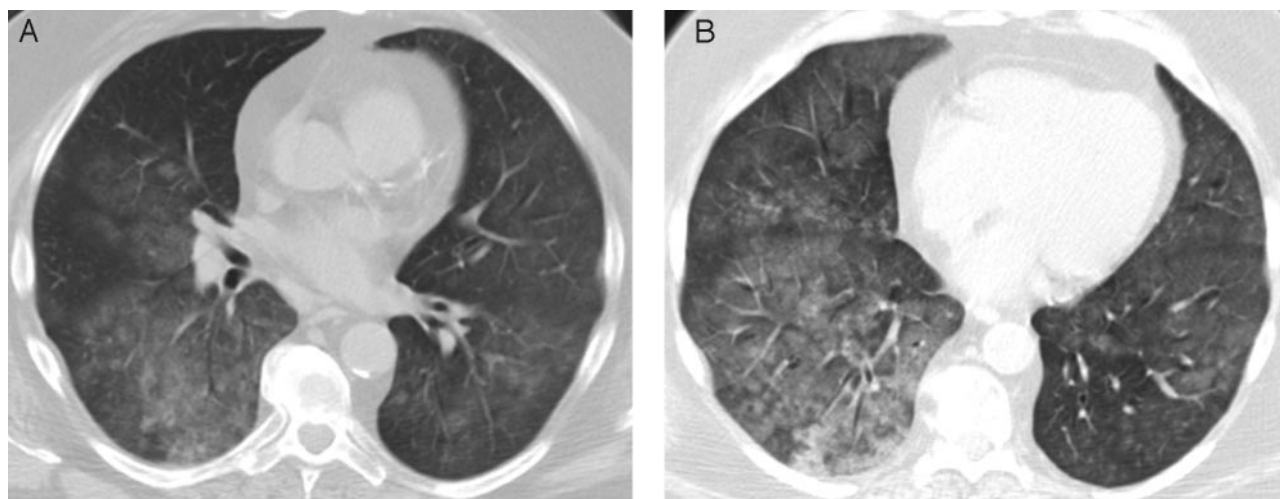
Two slices from the noncontrast high-resolution computed tomogram of the chest, showing diffuse bilateral ground-glass attenuation and interstitial infiltrates associated with giant-cell interstitial pneumonitis.
